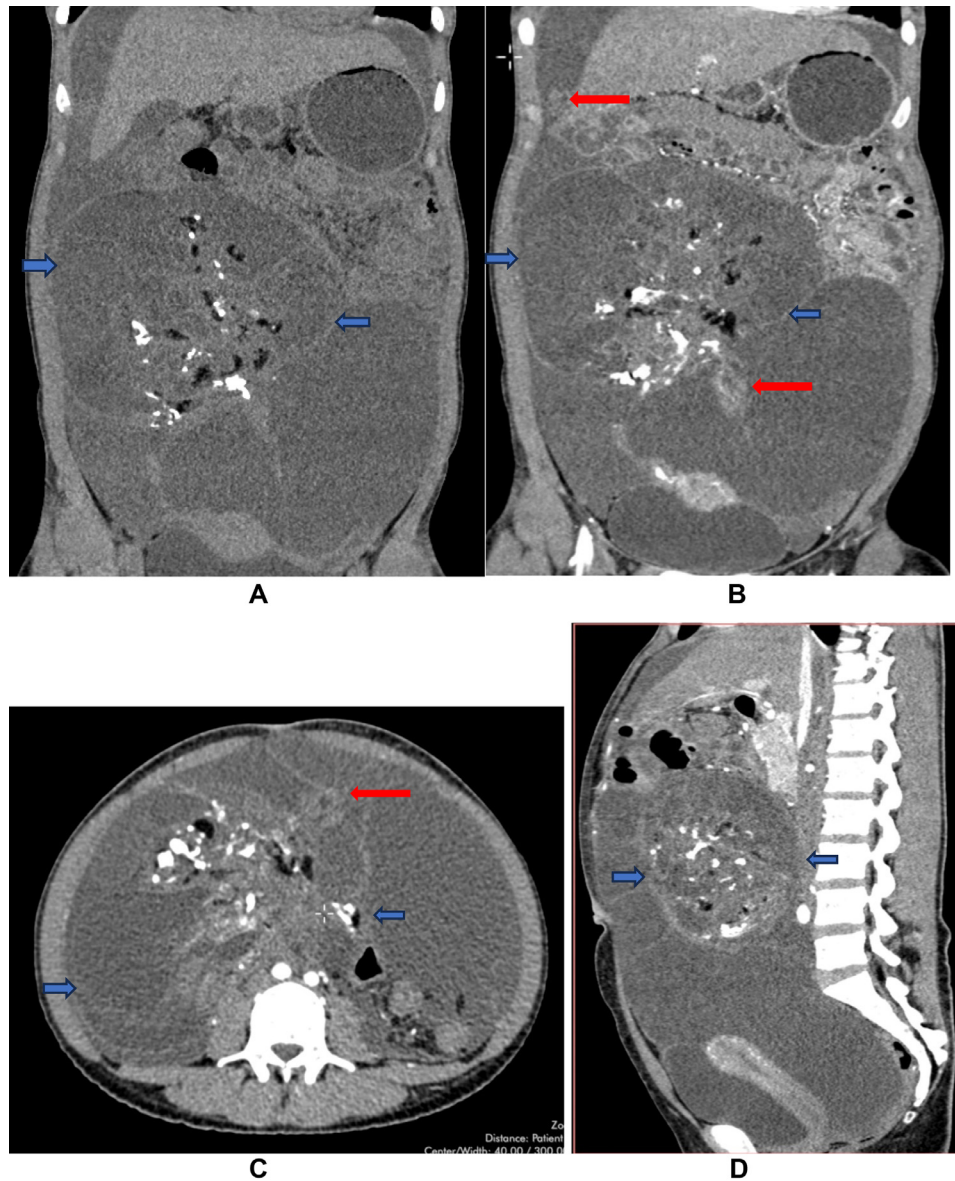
(A) Abdomen and pelvic non contrast computed tomography (CT) scan coronal view showing large well defined pelviabdominal solid cystic lesion (blue arrow) predominantly towards the right side with calcifications and fat components. Note the loculated gross ascites. (B) Abdomen and pelvic CE-CT scan coronal view showing the large well defined solid cystic lesion (blue arrow) in right side of abdomen and pelvis. The solid components and septa show enhancement. Note the irregular nodular peritoneal enhancement (gliomatosis peritonei, red arrow) and ascites. (C) Abdomen and pelvic CE-CT scan axial view showing the teratoma (blue arrow) with adjacent enhancing peritoneal nodules (red arrow) and ascites. (D) Abdomen and pelvic CE-CT scan sagittal view showing the teratoma (blue arrow) and loculated gross ascites.
